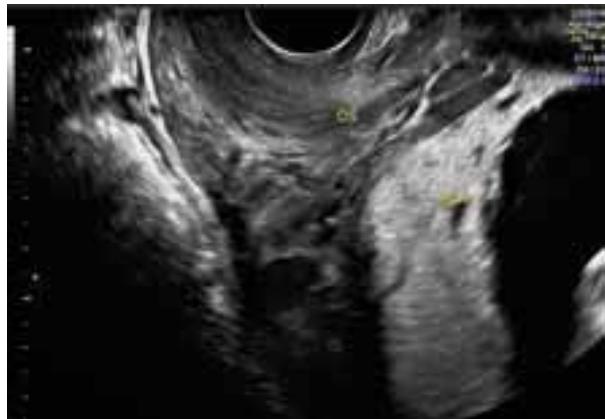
Transvaginal ultrasonography of placenta previa. The placenta (PLA) is seen covering the cervical os (OS). (Photo courtesy: Mediscan Systems, Chennai.)
